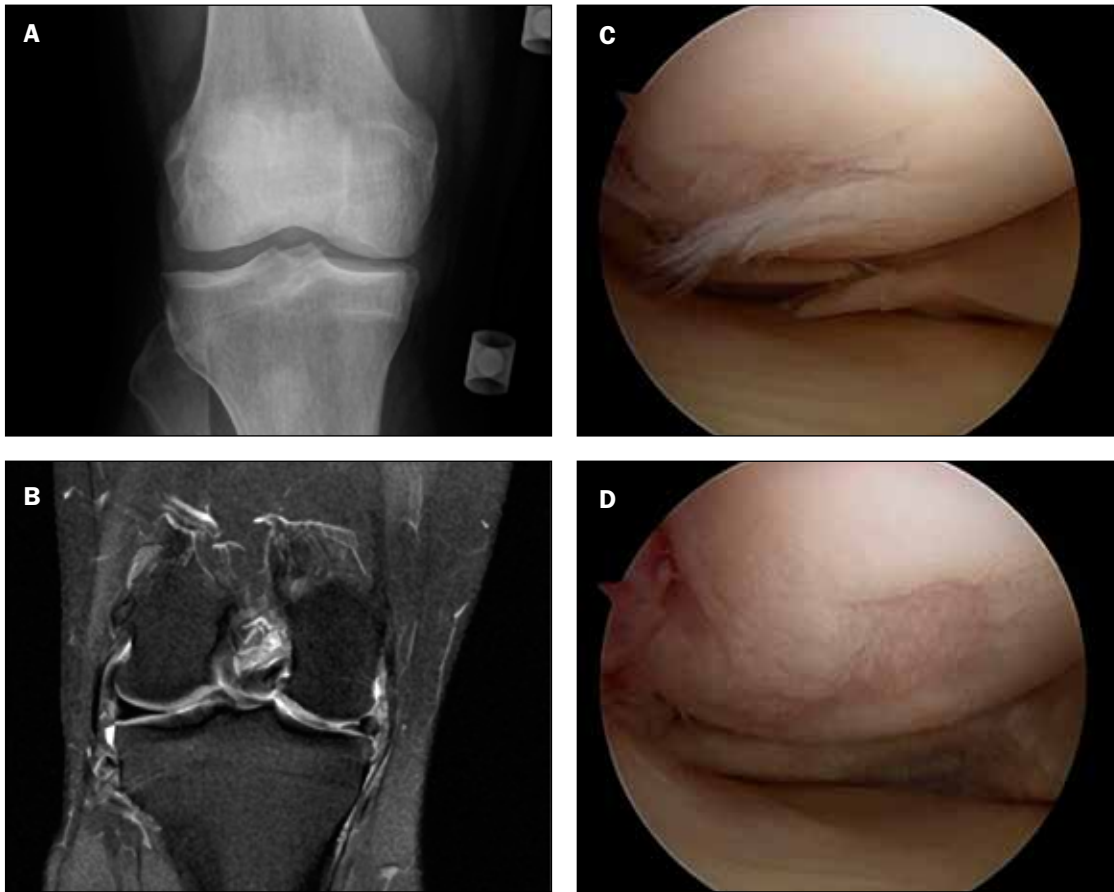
A, Standing x-ray showing medial compartment joint space narrowing (medial osteoarthritis). B, MRI showing medial meniscal tear and cartilage thinning of the femoral condyle. C, Intraoperative scope image of large cartilage flap and large meniscal tear. D, Intraoperative scope picture of cartilage débrided and meniscal tear resected.
